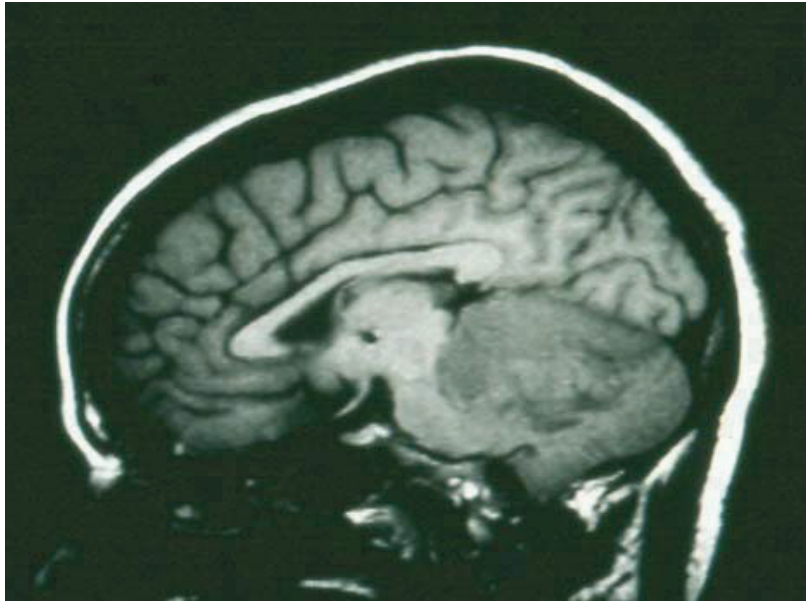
“Typical” medulloblastoma MRI.
